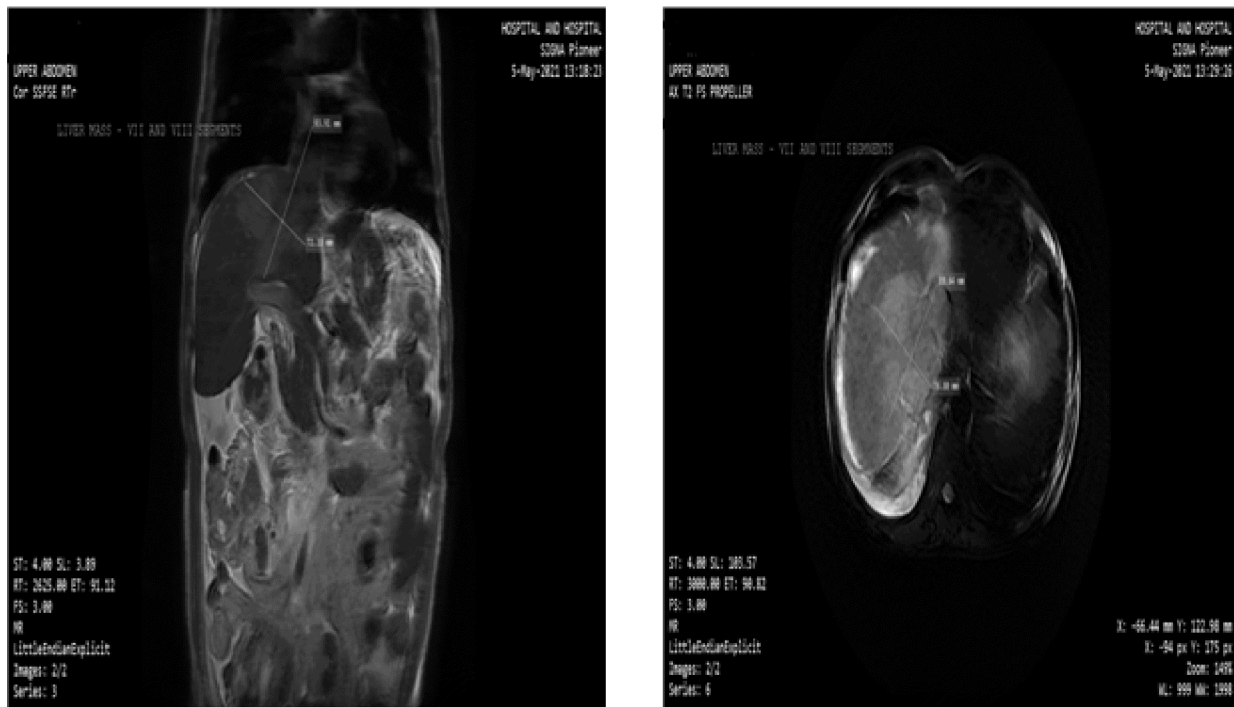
MRI upper abdomen - saggital view - showing large liver mass from VII and VIII segments extending to IVC and right atrium (sized 9.3 cm x 7.2 cm)
